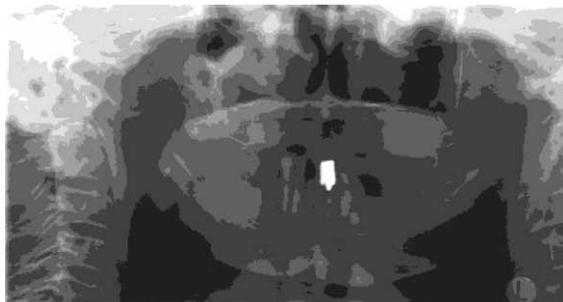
Oval osseous tumor in the region of right maxillary tuber showing typical soap bubble radiographic appearance.
